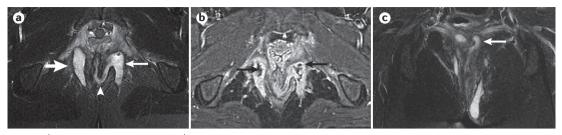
Complex perianal fistula. a | An axial T2-weighted image with fat saturation, showing a left trans-sphincteric fistula with a marked hyperintensity component on T2 sequence. The internal opening is located on the posterior aspect of the anal canal (arrowhead). There is an associated abscess in the left ischioanal fossa (long arrow). A second abscess in the right ischioanal fosa can be noted (short arrow) associated with another fistula tract (not seen). b | Image of the same fistula corresponds to an axial contrast-enhanced T1-weighted image showing lack of enhancement on the central part of the abscesses confirming the presence of pus (arrows). c | Coronal T2 fat-saturated image that depicts a left ischioanal roof extension. The rectal wall (not seen) was normal. The total van Assche MRI activity score was 18.
